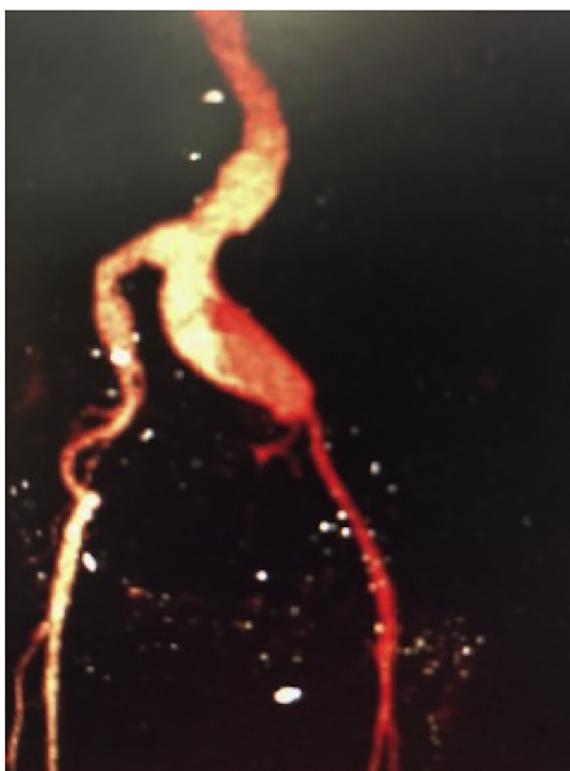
Follow-up CT angiography showing no leak.
